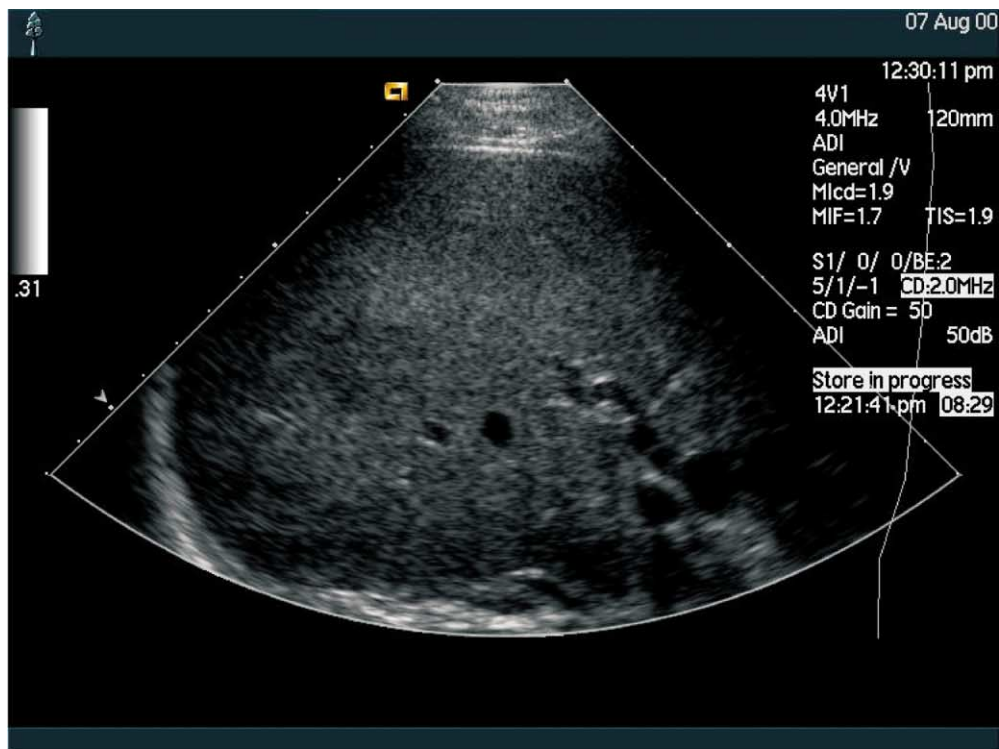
(a) Ultrasound of the liver in a case of suspected metastatic disease showed no definite lesion. When microbubble-specific data is overlain (b) using a microbubble which has a reticuloendothelial phase, a metastasis is seen as a defect (arrow). Many benign lesions show uptake and this can be used to distinguish between benign and malignant liver masses.
